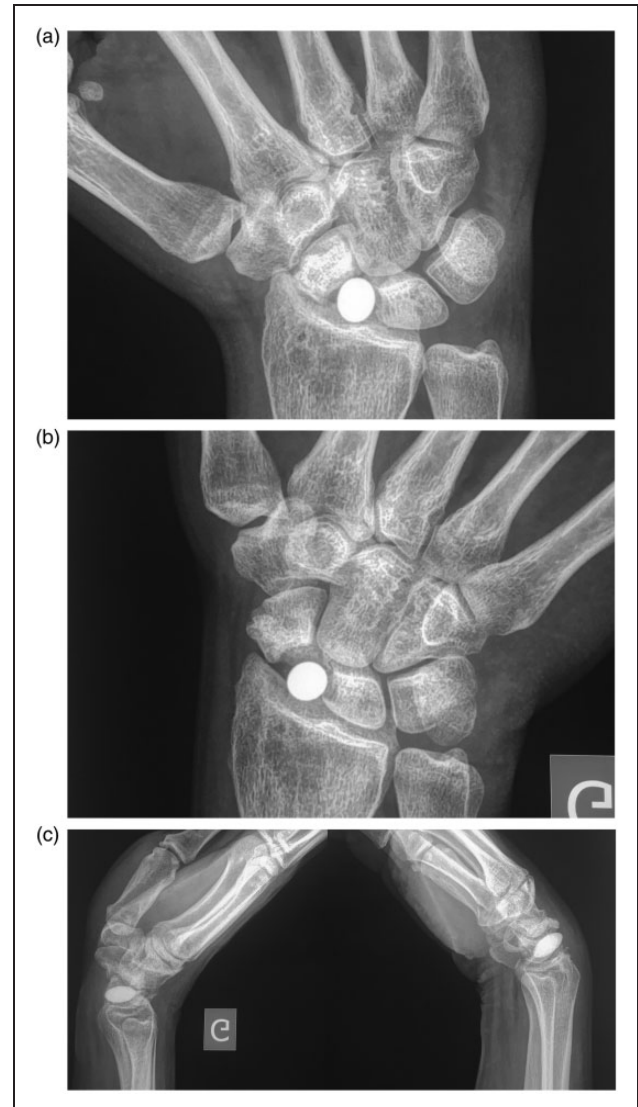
APSI implant after failed treatment for non-union of the proximal scaphoid. Dynamic radiographic views 5 years after surgery. (a) The wrist in radial deviation. (b) The wrist in ulnar deviation. (c) Lateral views in wrist flexion and extension.
